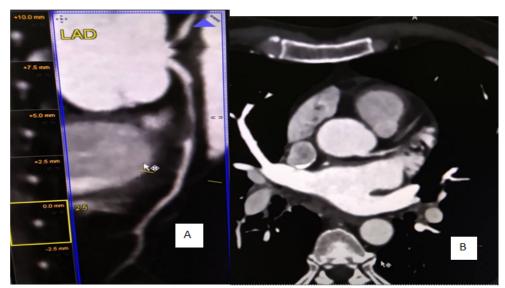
(Cardiac CT angiography): A & B images in the right shows- severe obstructive eccentric luminal narrowing in distal part of proximal segment of left anterior descending (LAD) artery due to non-calcified soft atheromatous plaque with negative remodeling
